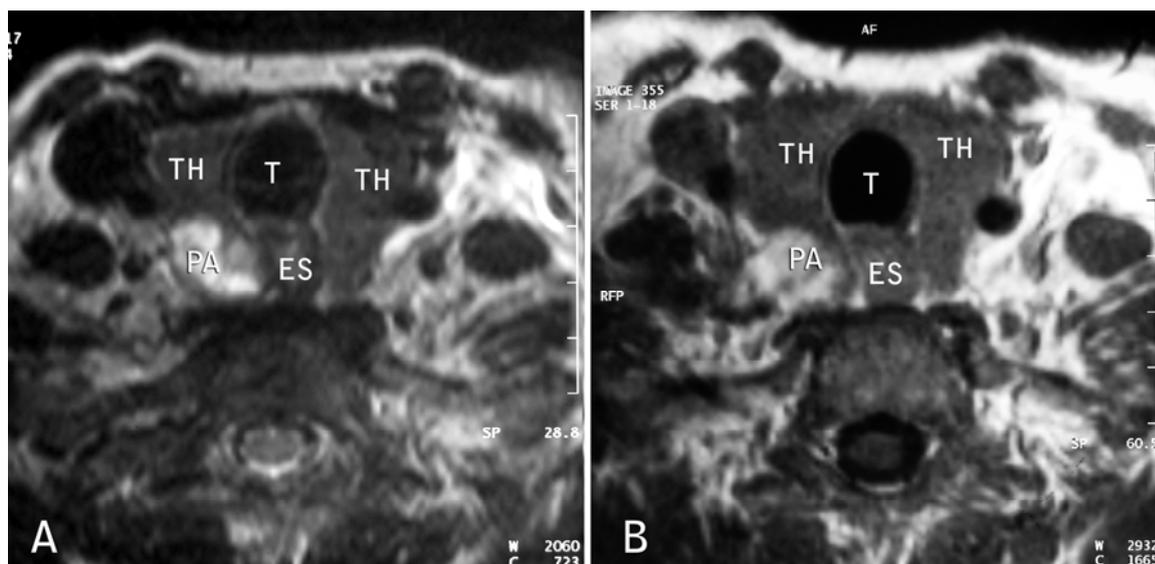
Axial MRI T2 weighted image (A) showing an adenoma (hyperintense), on the right of the inferior parathyroid gland while axial T1 weighted image with contrast (B) showing enhancement of the adenoma.
